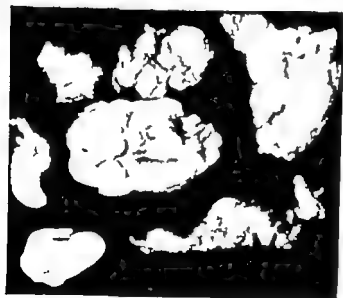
Osteochondromatosis. Case M. S., #38-10474 10 years, April, 1937 One month before admission repeated locking occurred in the left knee a large free body was palpable, and also visible in the x-ray. Arthrotomy was performed, and several large free bodies were found. The synovial membrane, which was greatly thickened, was removed together with the medial meniscus this resulted in full range of motion. However locking recurred 1½ years later X-ray again showed formation of free bodies. A second arthrotomy was done, with removal of five more cartilaginous bodies. Patient remained symptom-free until five years later when signs and symptoms of osteochondromatosis reappeared. X-ray revealed additional loose bodies.
